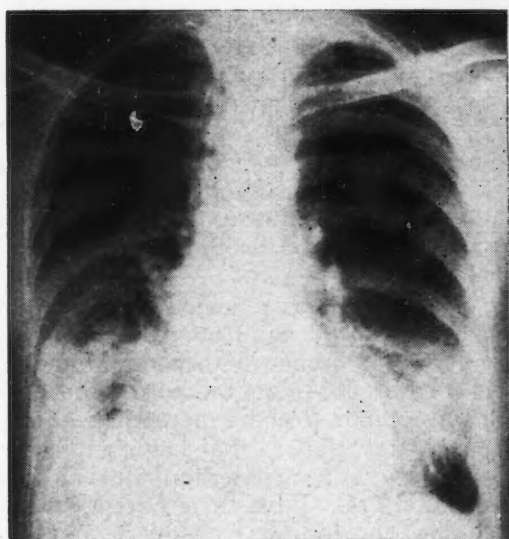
Chest radiograph on June 28, showing right pleural effusion. Fig. 4.—Radiograph on July 19, showing improvement.
